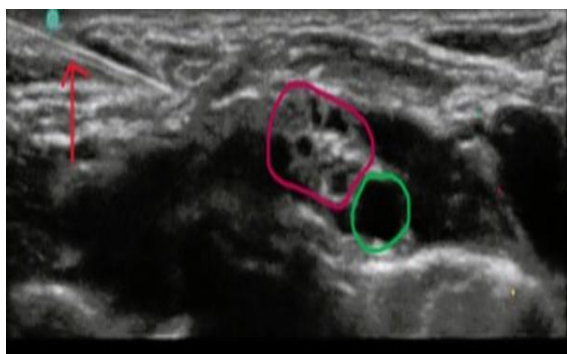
Ultrasound image of brachial plexus in parasagittal approach
